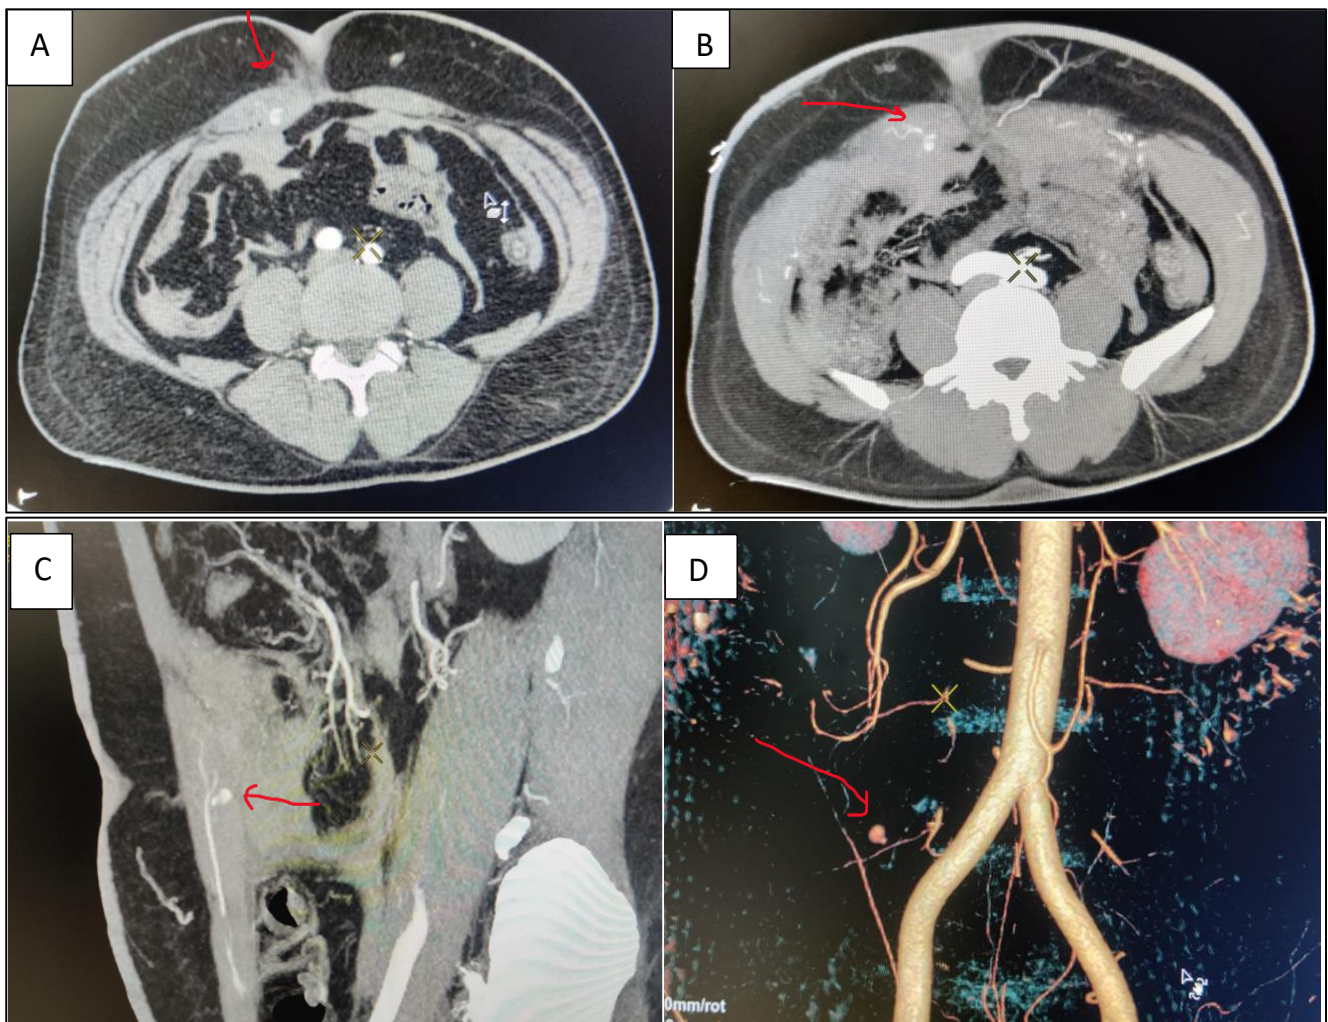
(A-D): CT Angiography (MIP and 3D reconstruction images): A and B axial, C sagittal and D-3D reconstruction images showing small pseudoaneurysm (red arrow) arising from small branch of the right inferior epigastric artery.
